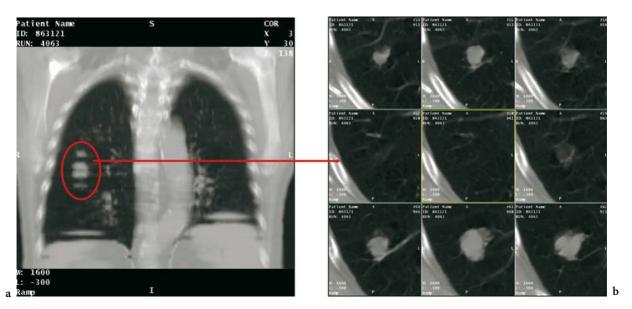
a Distorted image of a peripheral lung tumor captured on a spiral CT scan (1 s/slice). b Tumor movements during scan acquisition account for the 'missing' tumor volume in intermediate slices
